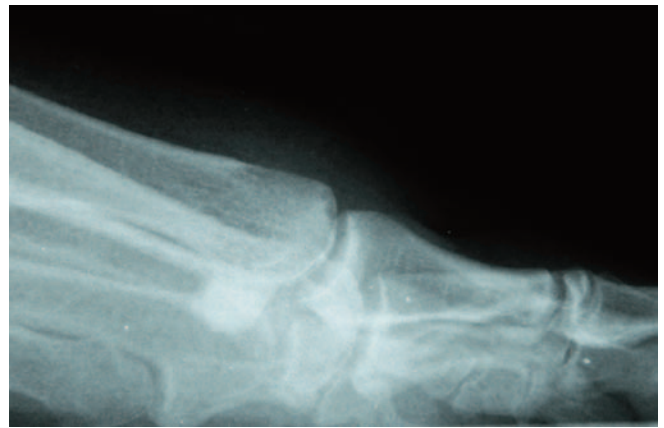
Case Study 3. Postoperative lateral radiograph.
